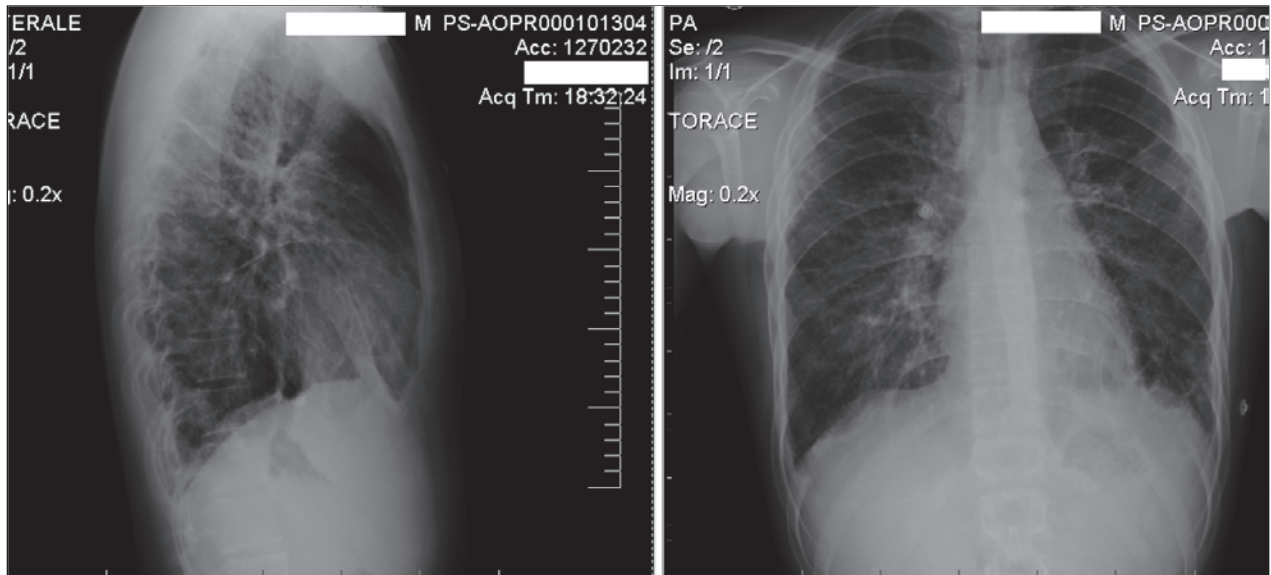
Posteroanterior and lateral chest-X-ray: bilateral interstitial opacities, dilatation of the azygos vein and mild cardiac enlargement.
